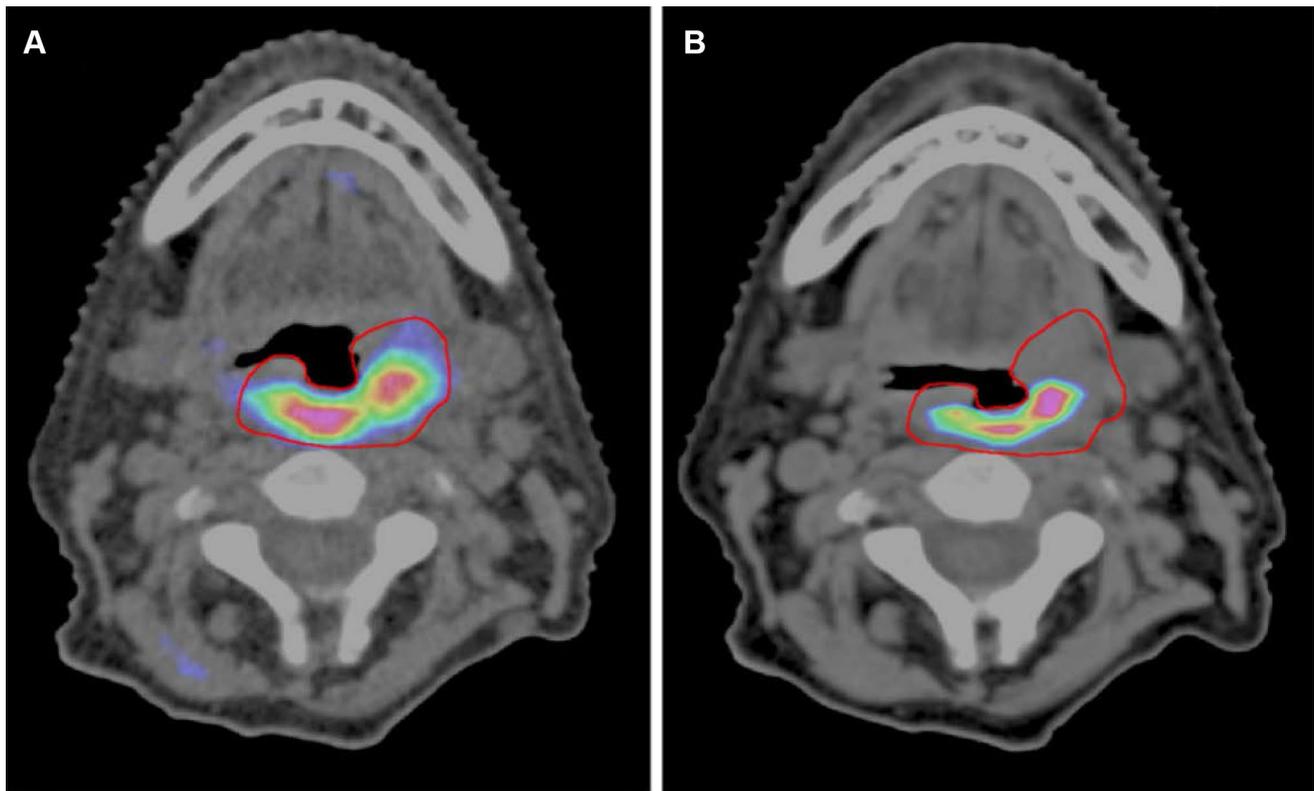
FAZA PET-CT images of a patient with an oropharyngeal p16-negative squamous cell carcinoma. The patient was imaged 2 h after injection of 10 mCi of FAZA. a Baseline image; b image taken
